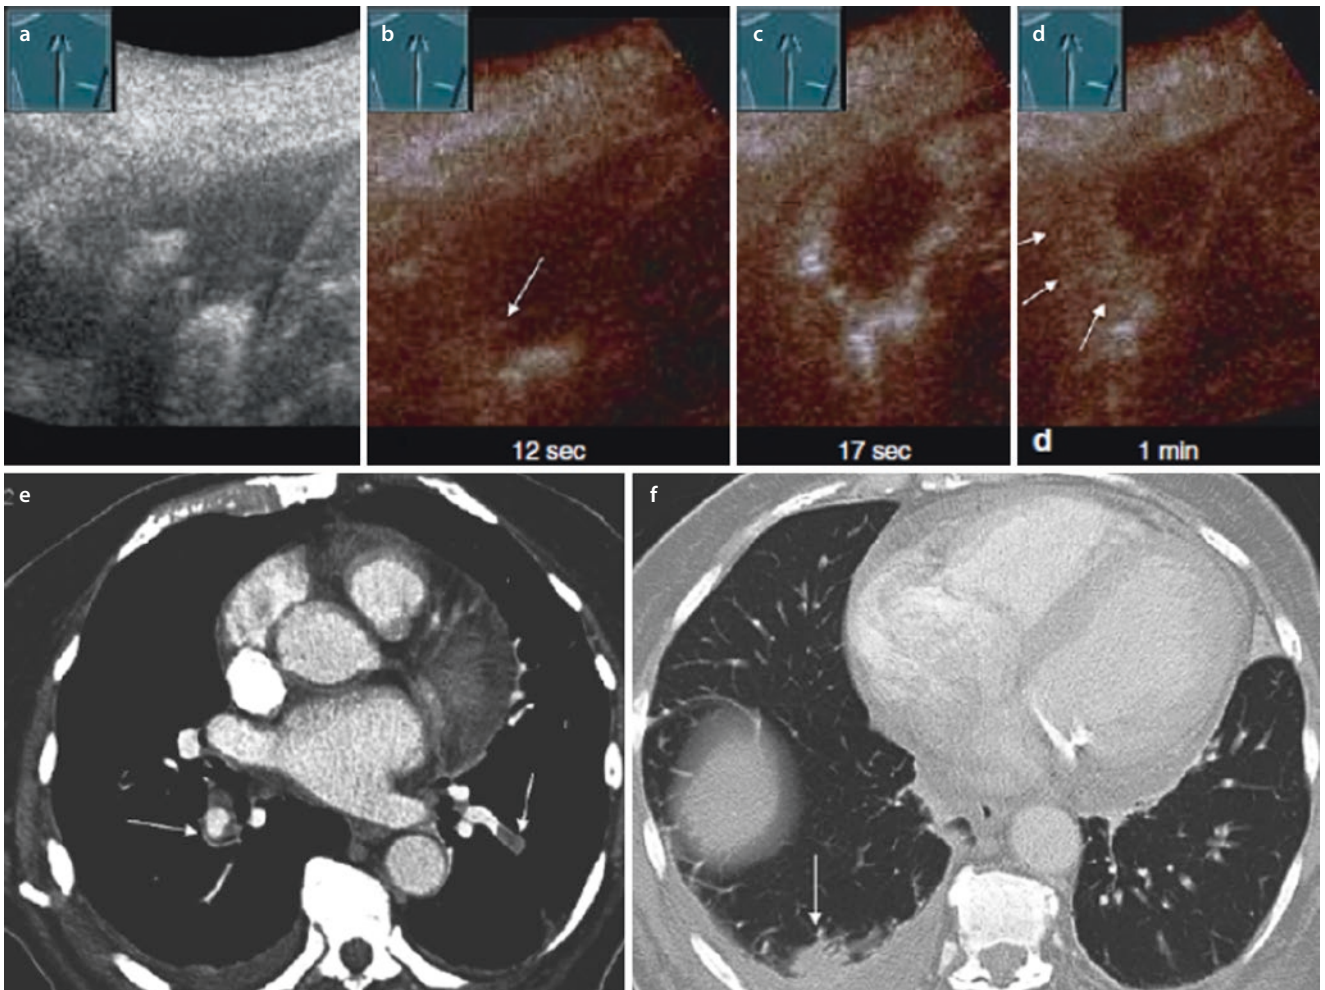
Patient with breath-dependent pain and suspected pleurisy. a The B-mode ultrasound image reveals a long, irregular entry echo in the lower lobe of the right lung. b Contrast-assisted
